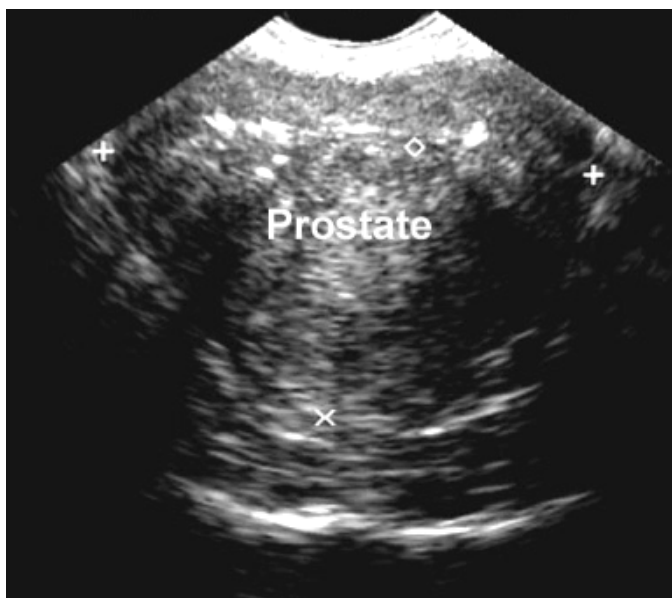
Ultrasound Image of the prostate indicates the poor sensitivity for PCa detection.
